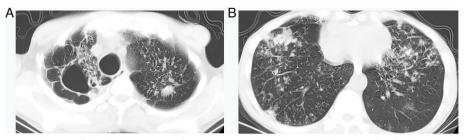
Computed tomography scan of the thorax in case 23. There is a cavity in the right upper lobe (A), and multiple spots, nodules, and cords were observed in both lungs (A, B). Dilated bronchi were shown in some segments of the bronchus
